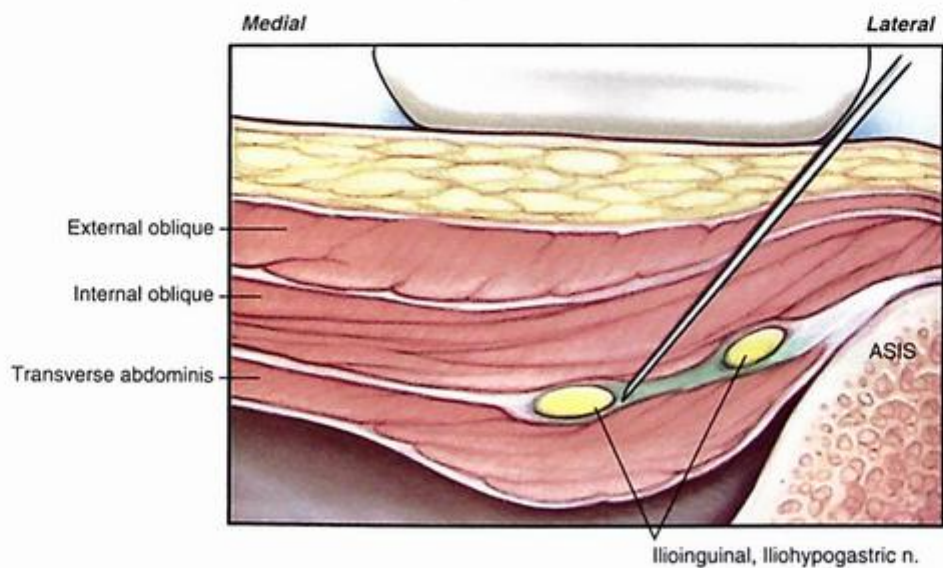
The needle is advanced under ultrasound using an in-plane approach, penetrating the external and internal oblique muscles, targeting the ilioinguinal and iliohypogastric nerves lying in the plane between the internal oblique and the transverse abdominis muscles. ASIS, Anterosuperior iliac spine.
